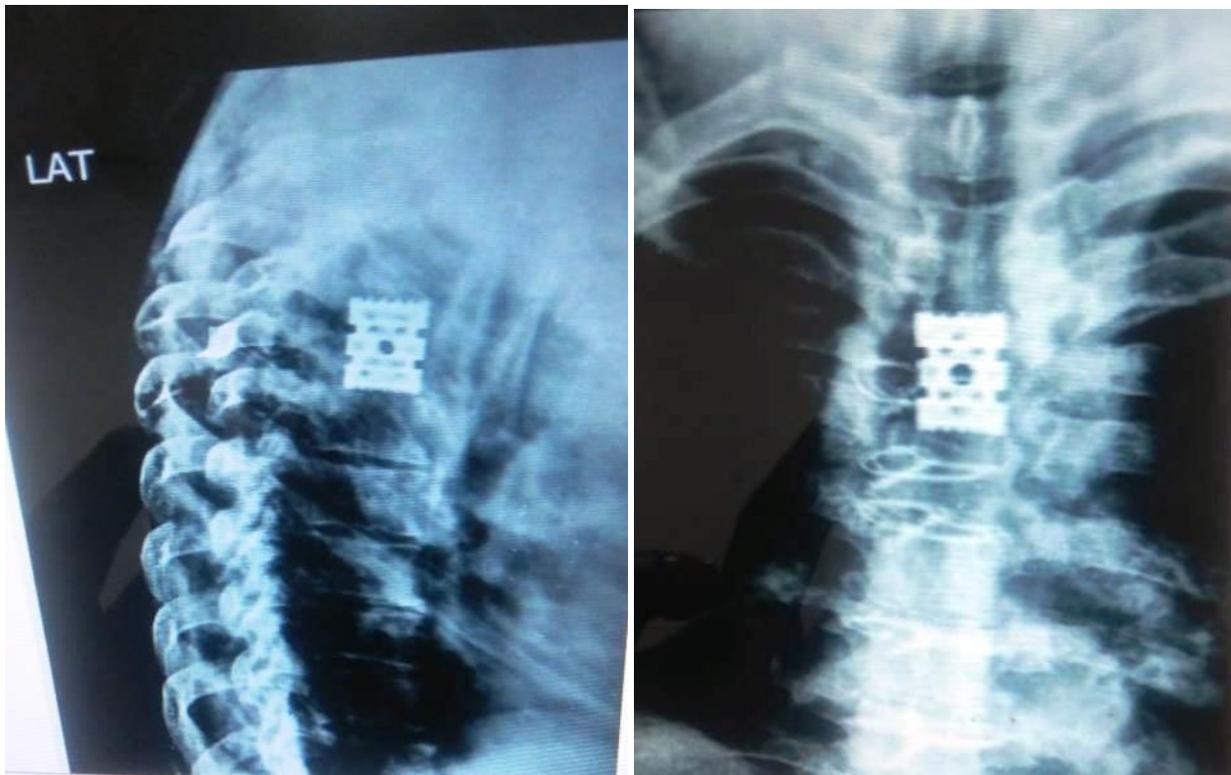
X-Ray Post-Operative Thoracic Spine Lateral and AP view.
